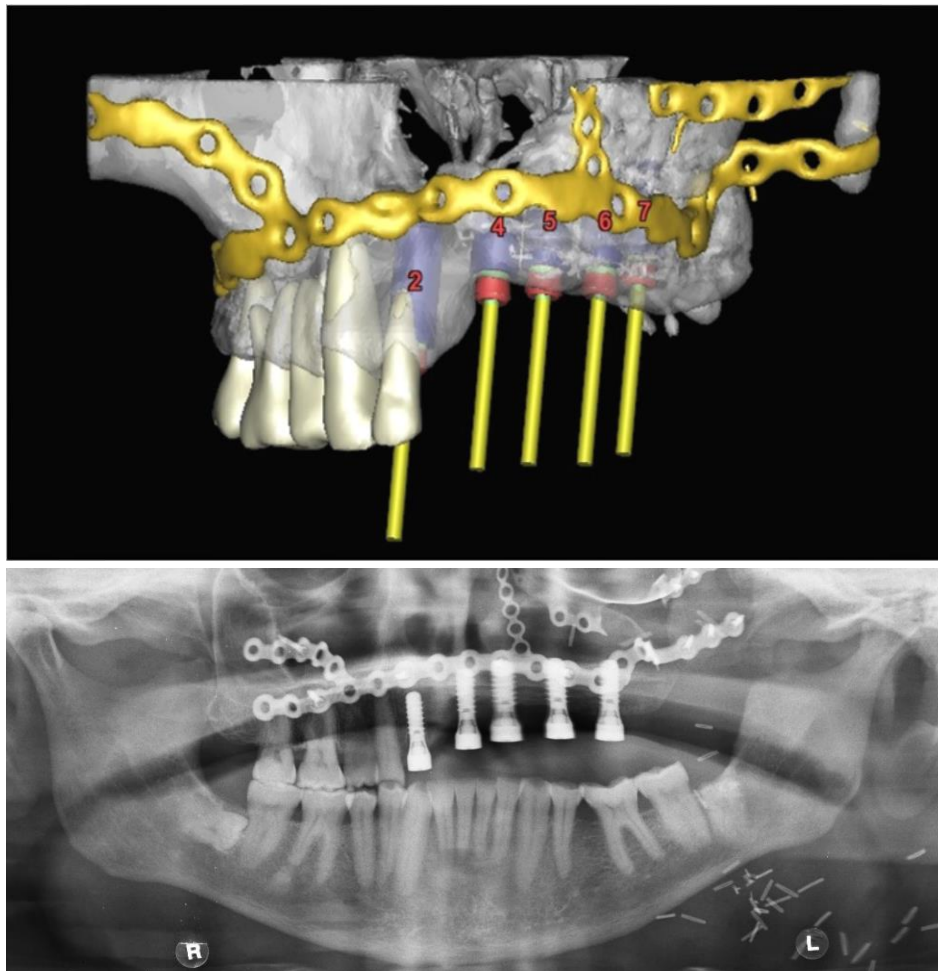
Demonstrating the use of SIMPLANT planning software with a reformatted CBCT to plan implant placement into a DCIA flap and into native bone. Post-operative OPT radiograph shows optimal implant position for restoration as planned.
